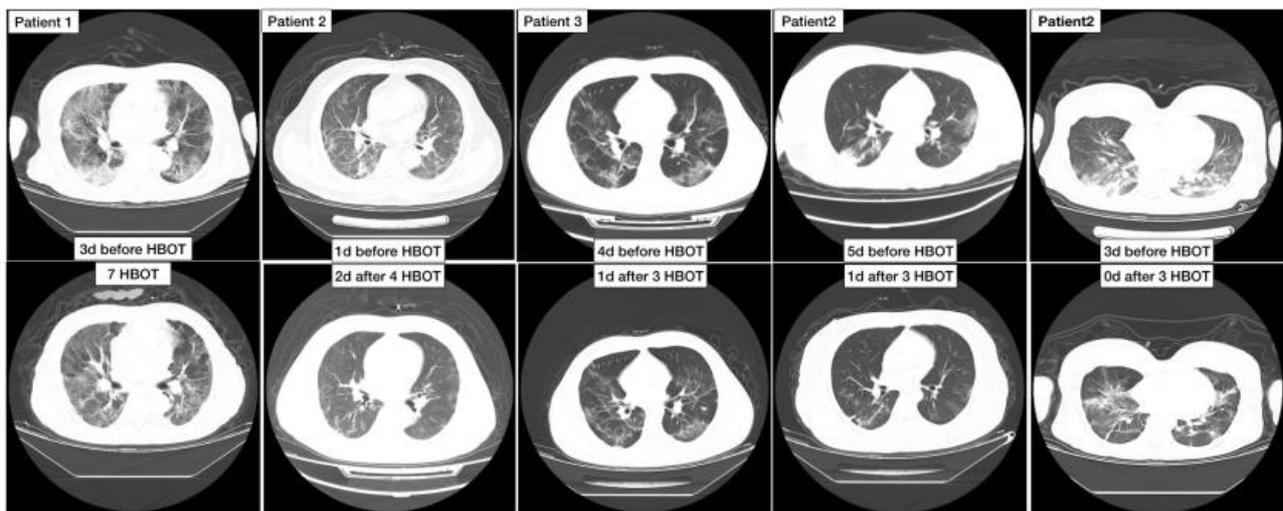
Chest CT imaging of 5 patients before and after HBO2
